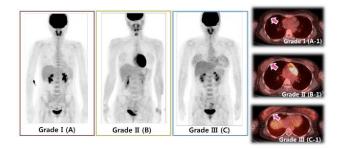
Three nuclear medicine specialists performed the blind test. (A), (B), (C) were PET whole body images, and (A-1, B-1, C-1) were the fusion image of each grade. The unusually Breast FDG uptake increased with increasing grade.
